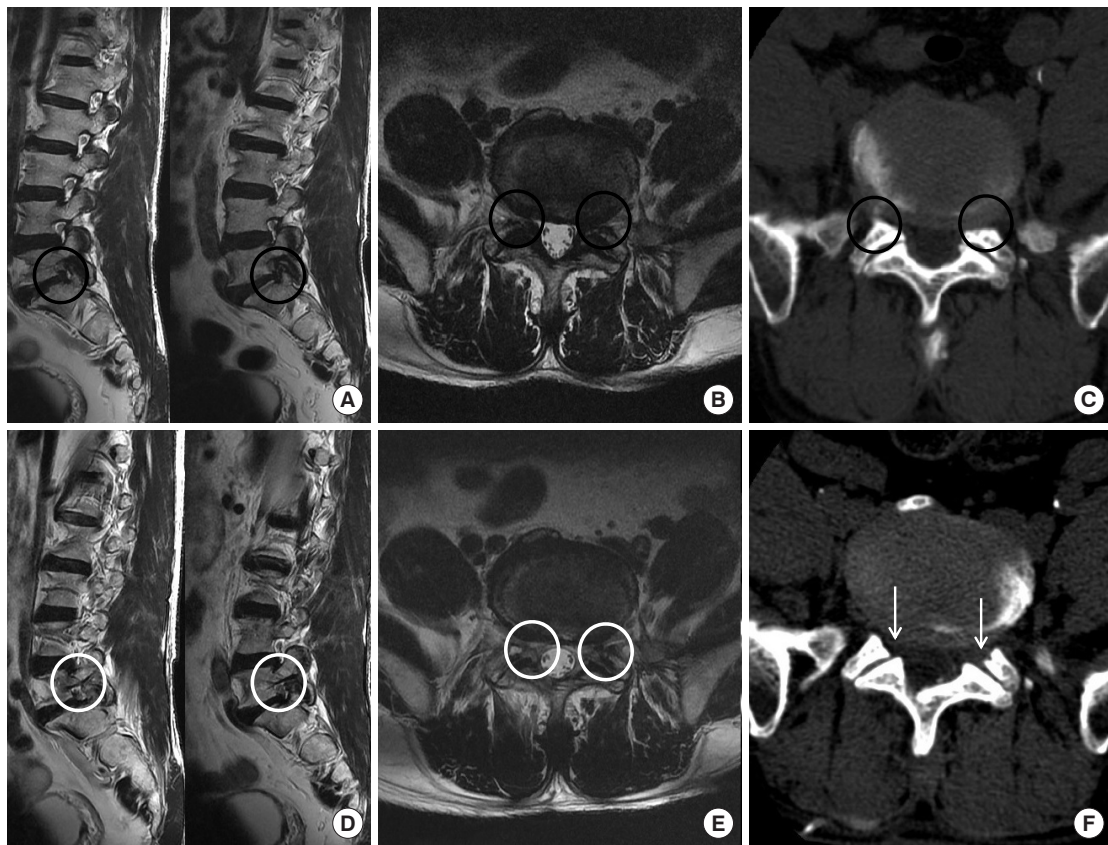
Pre- and postoperative radiologic images of the first case. (A) Preoperative parasagittal T2-weighted magnetic resonance imaging (MRI) image. (B) Preoperative axial T2-weighted MRI image. (C) Preoperative axial computed tomography (CT) image. (D) Postoperative parasagittal T2-weighted MRI image. (E) Postoperative axial. (F) Postoperative axial CT image of resected superior articular process. Black circles: compressed areas of bilateral L5 nerve root by L5–S1 foraminal stenosis. White circles: decompressed foraminal areas for bilateral L5 exiting roots. White arrows: resected areas of bilateral superior articular process of S1.
